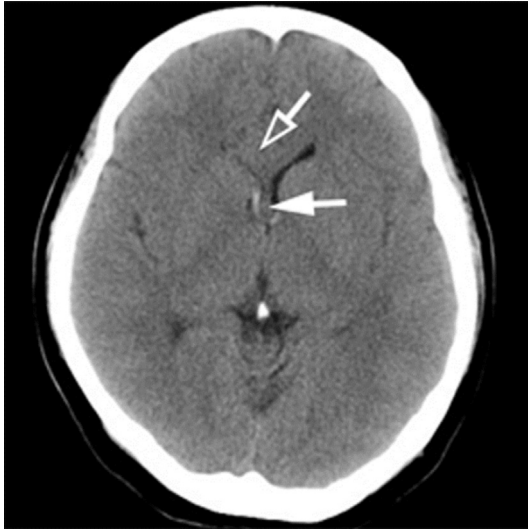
A CT scan at admission (17 weeks of gestation) showed a small hemorrhage along the margin of the right lateral ventricle (solid arrow) and a space-occupying lesion displacing the right frontal horn of the lateral ventricle posteriorly (open arrow).
